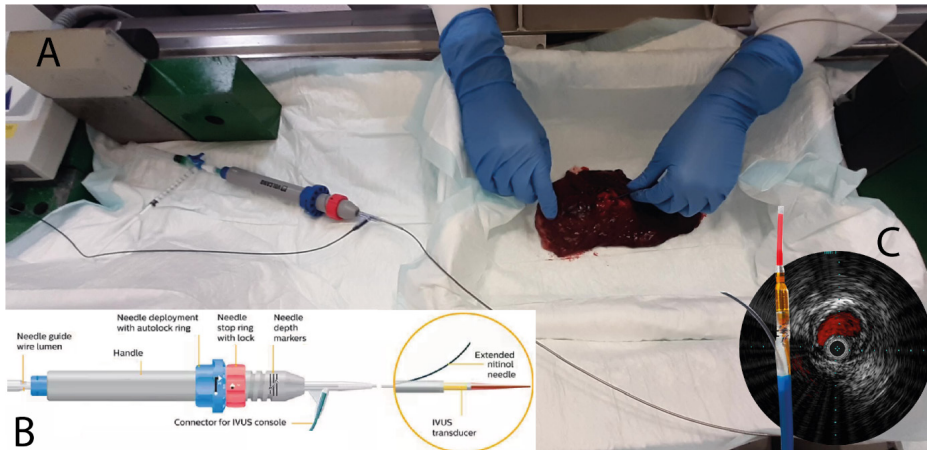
Visualization of the experimental set-up. (A) Experiment set-up with on the left a syringe filled with ^{99m}Tc -ICG-nanocolloid and a syringe filled with saline connected with a three-way valve to the Pioneer Plus catheter leading to the resected lung tissue on the right. (B) Pioneer Plus catheter features with a needle guidewire lumen that has a Luer-lock. (C) Example IVUS-image obtained with the transducer, as depicted in yellow.[64] (B,C) were adapted from Philips product information with the permission of Philips. IVUS, intravascular ultrasound; ICG, indocyanine green.
